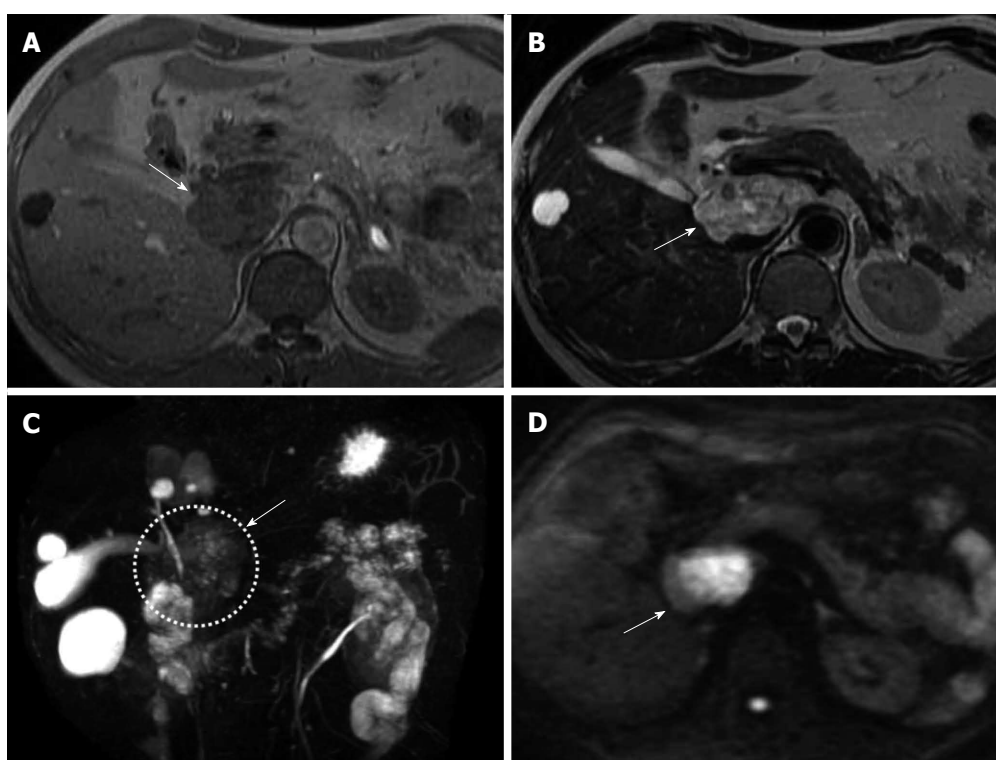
Findings of patient #4. A: Findings of T1-weighted imaging on magnetic resonance imaging (MRI). T1-weighted imaging of patient showed a higher intensity than free water (arrow); B: Findings of T2-weighted imaging on MRI. T2-weighted imaging of patient showed a lower intensity than free water (arrow); C: Findings of magnetic resonance cholangiopancreatography (MRCP). MRCP of patient showed a lower intensity than free water (arrow); D: Findings of diffusion-weighted imaging on MRI (arrow). Diffusion-weighted imaging of three patients showed a higher intensity than free water. The cystic lesions showed high intense signal in the central part and iso-intense in the periphery.
